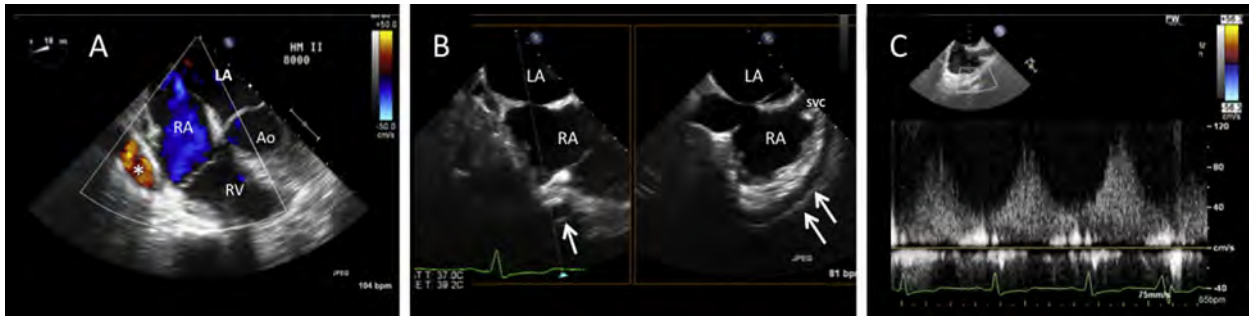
LVAD outflow graft, as assessed by TEE. (A,B) In a modified mid-esophageal 4-chamber view (A), the outflow graft (*) is frequently seen in near short-axis orientation. See also [Video 14](#). (B) Shows the utility of simultaneous orthogonal-plane imaging, which, in this case, a short axis image of the outflow graft (single arrow) is used as a reference image to reveal a long segment of the graft overlying the RA in a standard bicaval view (double arrows). See also [Video 15](#). (C) Successful pulsed Doppler interrogation of the outflow graft (this is not always possible in practice). See also [Video 16](#).
